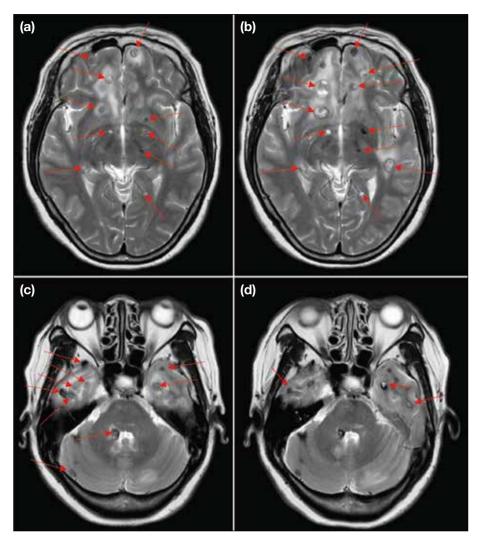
Figure One-month posttreatment T2-weighted image (taken in February 2022) shows multiple lesions in the frontal lobes. Five-month posttreatment image (taken in June 2022) shows interval enlargement of these lesions and a new left inferior parietal lobe lesion. Note the increase in vasogenic oedema. (c) Onemonth posttreatment T2-weighted image shows multiple lesions in the bilateral temporal lobes and cerebellum (arrows). (d) Five-month posttreatment image shows interval regression of some of the temporal lobe lesions (arrows), with interval reduction in vasogenic oedema.
